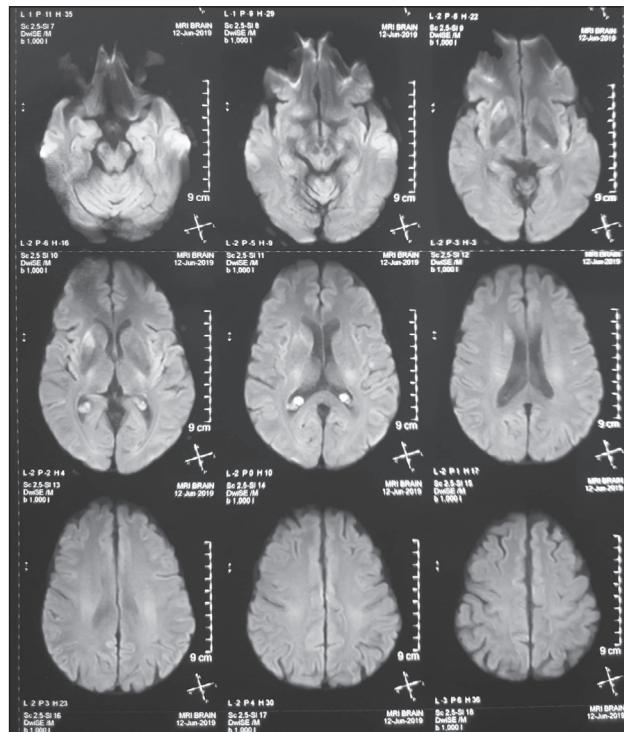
Brain MRI (T2/FLAIR, axial plane) showing hyperintensity in the region of the right basal ganglia/putamen.
